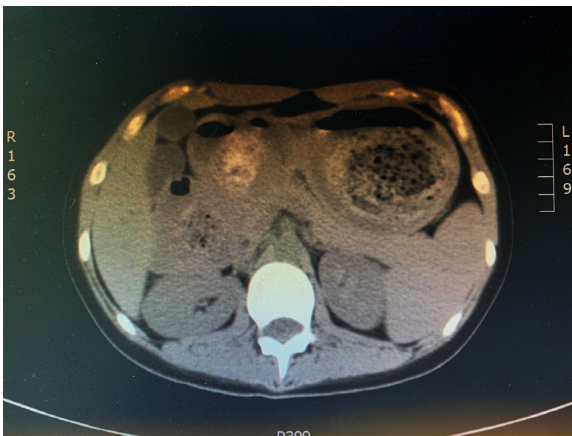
Axial computed tomography image demonstrating a large heterogenous intraluminal mass obstructing the entire lumen of the stomach.
